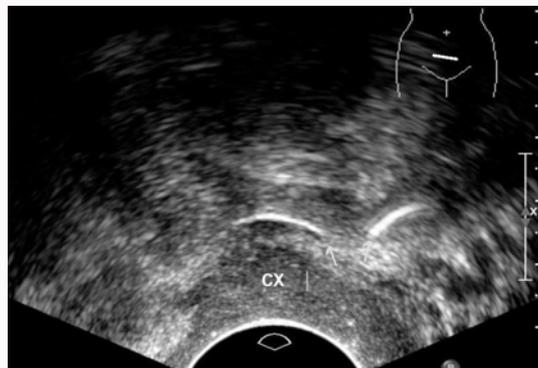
Both transvaginal ultrasound and abdominal X-ray revealed a displaced IUD to left lower pelvic area.
